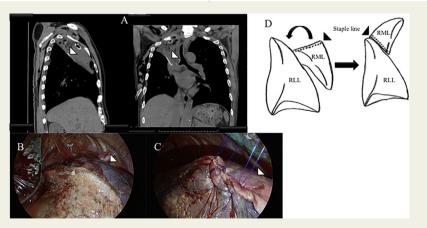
(A) Sagittal and coronal sections of computed tomography reconstructions for the diagnosis of middle lobe torsion reveal the inappropriate direction of the staple line (arrow heads) of the middle lobe. (B) The right middle lobe was twisted approximately 150° counter-clockwise (arrowhead). (C) The surface colour and compliance of the middle lobe improved after detorsion (arrowhead). We performed detorsion and fixation between the middle lobe and the lower lobe by sutures. (D) Scheme of right middle lobe torsion.
